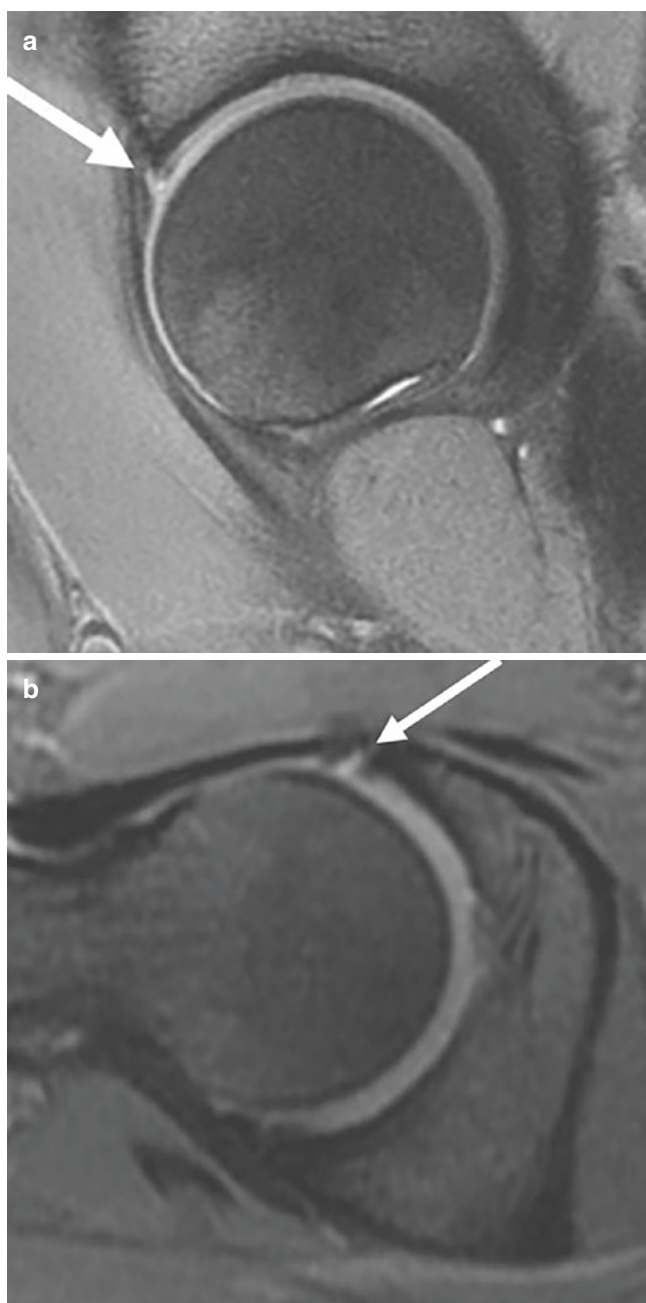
Sagittal (a) and axial oblique (b) PD fat-suppressed MR images in a 22-year-old woman with hip pain shows linear high signal across the labral base representing labral injury (arrow)
